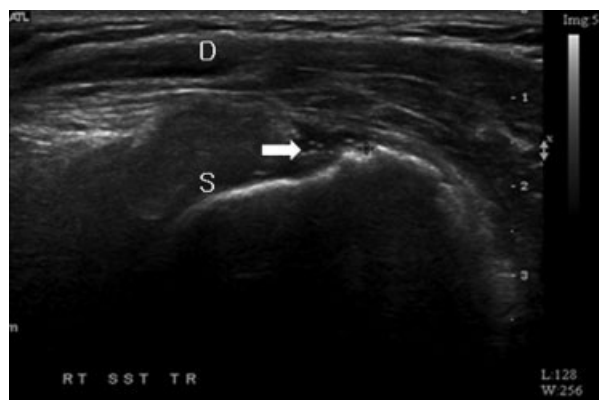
Transverse ultrasonography of the supraspinatus tendon shows a partial thickness tear (arrow) in the supraspinatus tendon (S). The overlying deltoid muscle (D) is seen.
